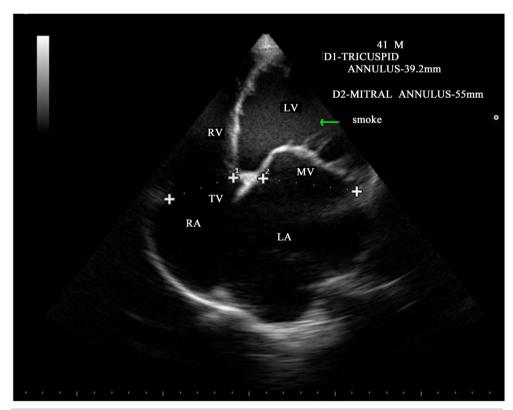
Apical four chamber view showing the "smoke" in the left ventricle.
